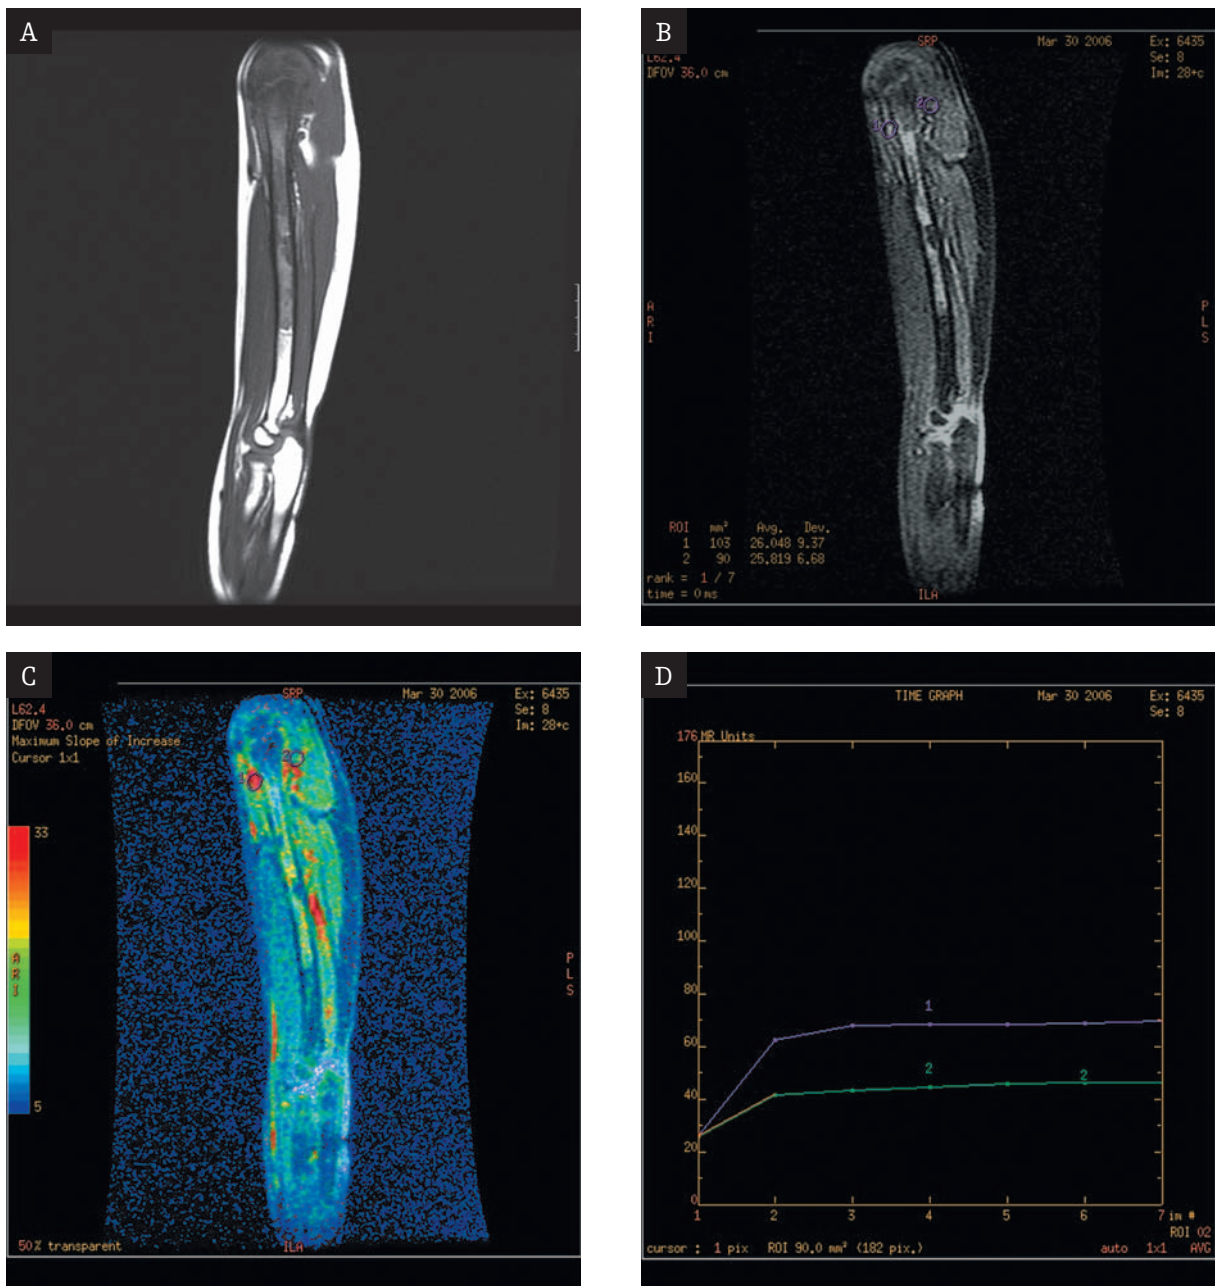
Ewing's sa of the humerus. MRI during initial chth, sagittal plane. A. T1WI. The extracortical tumor involves ½ of the bone, infiltration of the medullary cavity – 2/3. B. T1WI, FATSAT – part of dynamic examination. C. Color-coded contrast enhancement of the extracortical tumor on dynamic examination. D. The curve of contrast enhancement in a suspicious focus (1) is not typical of viable tumour tissue.
